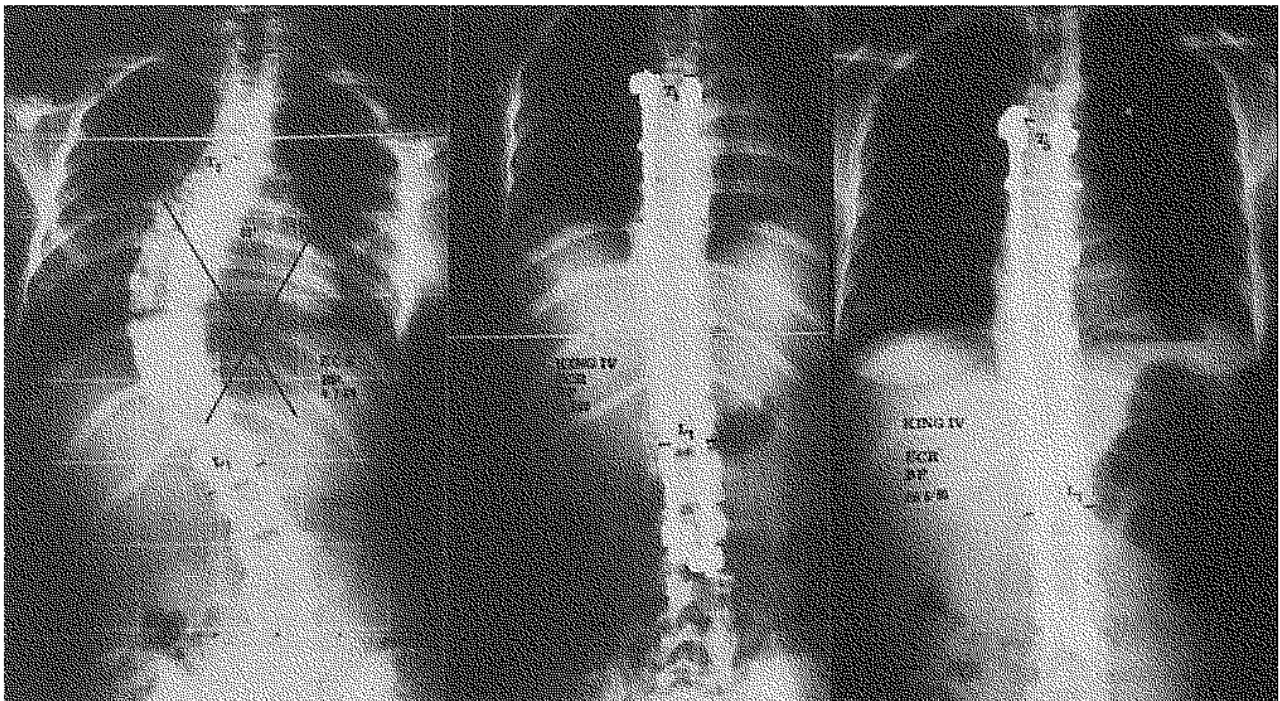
Preoperative, postoperative and follow-up standing anteroposterior radiographs of a 14-year-old girl with a King type IV curve. The postoperative correction was excellent with minimum loss after 6 years.
